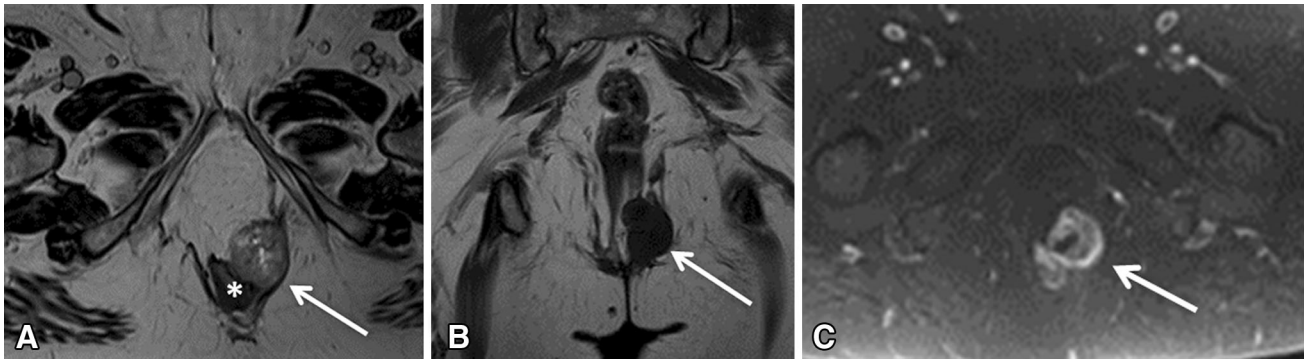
Biopsy proven melanoma metastasis to the perirectal region. Patient had a history of vaginal melanoma with pelvic floor reconstruction. A Axial small field of view T2-weighted image demonstrates a mixed T2 signal mass displacing the rectum (asterisk) towards the right and the pelvic floor
